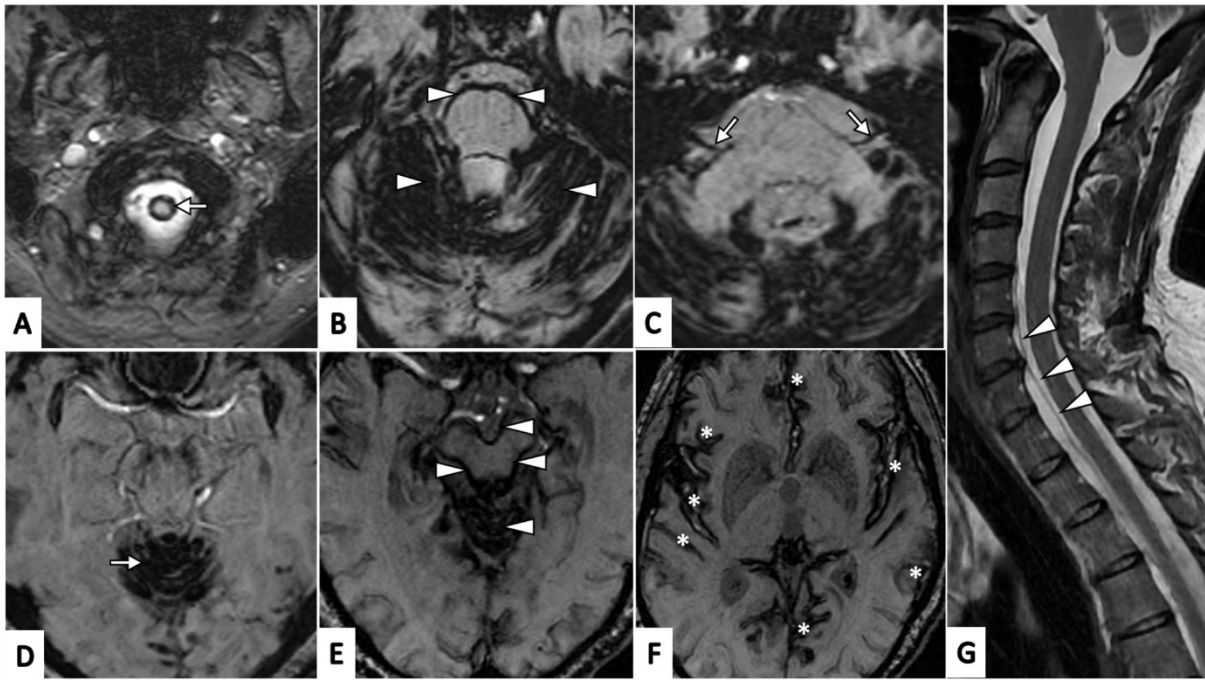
Typical (classical) radiological appearances of haemosiderin deposits in infratentorial superficial siderosis (axial susceptibility weighted MR images, SW MRI, A-F): A. Craniocervical junction (arrow); B. Haemosiderin involving cerebellar folia with a rim of haemosiderin surrounding the pons (all marked with arrow heads); C. Haemosiderin involving the vestibulo-cochlear nerves (CN VIII) bilaterally (arrows); D. Haemosiderin involving superior vermis (arrow); E. Haemosiderin involving superior vermis with a rim of haemosiderin surrounding the midbrain (all marked with arrowheads); F. Haemosiderin involving supratentorial regions (including the Sylvian fissures, temporal and frontal lobes and cingulate gyri, all marked with asterisks); G. Saggital T2-weighted MRI demonstrating ventral cerebrospinal fluid spinal collection (arrowheads).
